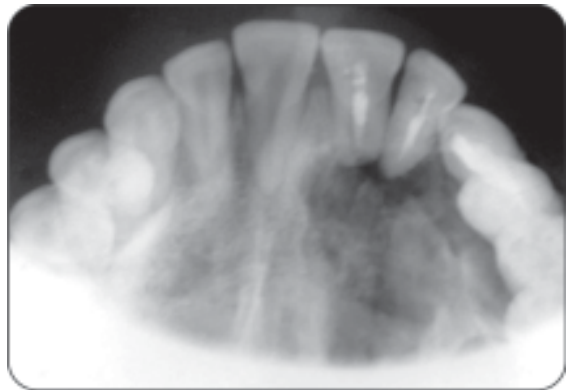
Radiograph of squamous odontogenic tumor
